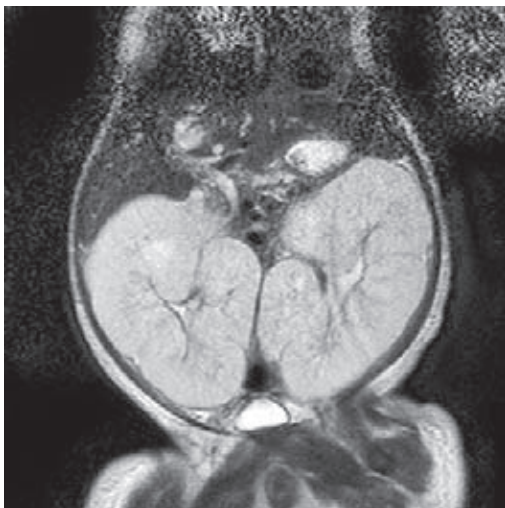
Autosomal recessive polycystic kidney disease on abdominal MR scan. Coronal T2-weighted abdominal MR image from the same patient, shows the extent of the bilateral nephromegaly
